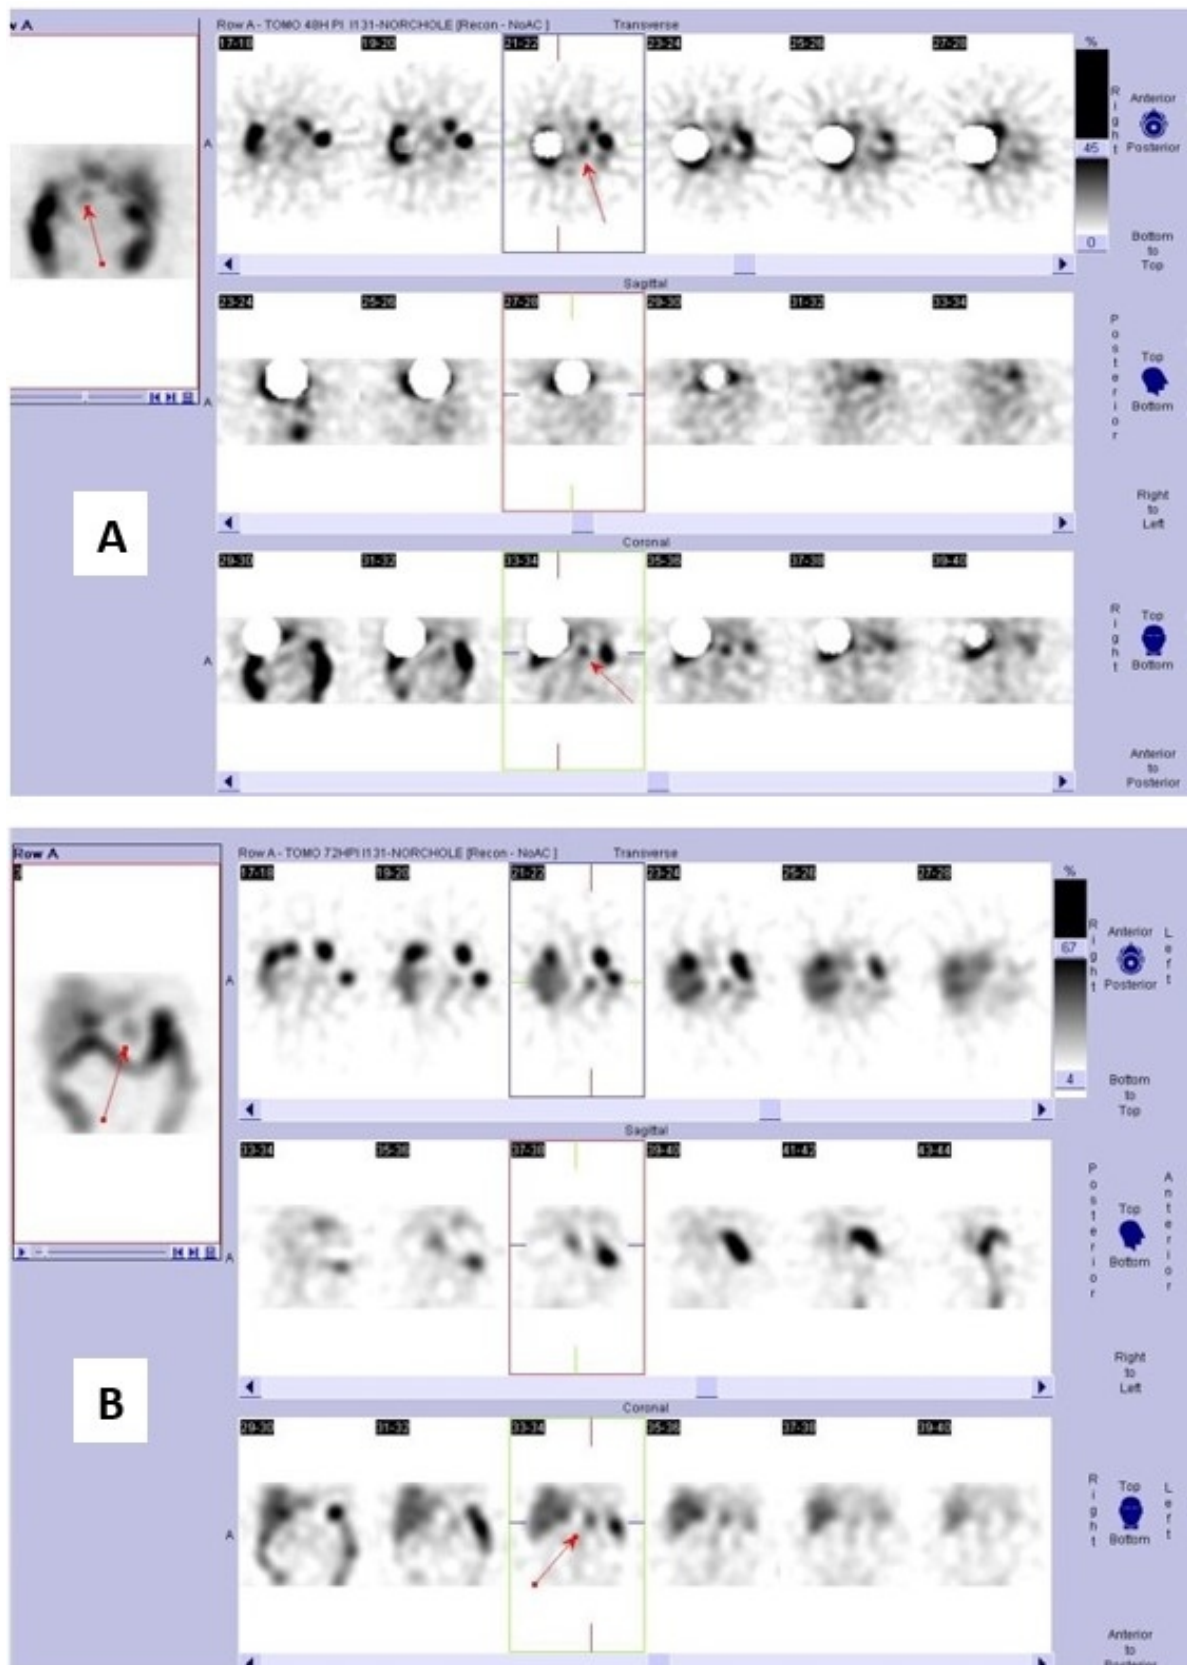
Single photon emission computed tomography at 48h (A): At transverse and coronal slices as well as at cine-mode snapshot (left outer image) the pointed hot spot sign (arrow) represents the visualized left adrenal cortex (adenoma). In order to enhance the contrast, partial masking of liver has been applied. Single photon emission computed tomography at 72h (B): At coronal slices as well as at cine-mode snapshot (left outer image), the pointed hot spot sign (arrow) represents the visualized left adrenal cortex (adenoma). Notice that gallbladder still remains visible, but comparing to SPECT imaging at 48h, left adrenal cortex (adenoma) is better seen, because of more faded hepatic background. This justifies the value of late imaging, as well as that of SPECT acquisition in order to have an optimum imaging result (without underlying background, and/or normal overlapping structures – e.g. gallbladder).
